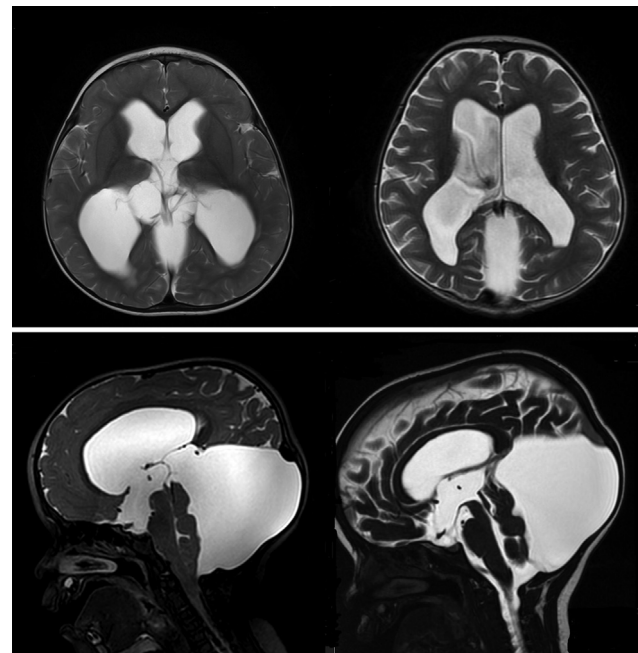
The magnetic resonance imaging T2-weighted images (axial above and mid-sagittal below) showing the preoperative images on the left and the postoperative images performed 3 months after surgery on the right side for comparison. The ventricles are smaller with more prominent sulci. The floor of the third ventricle has more definition, and the aqueduct of Sylvius is open. The retrocerebellar cyst is also smaller.
